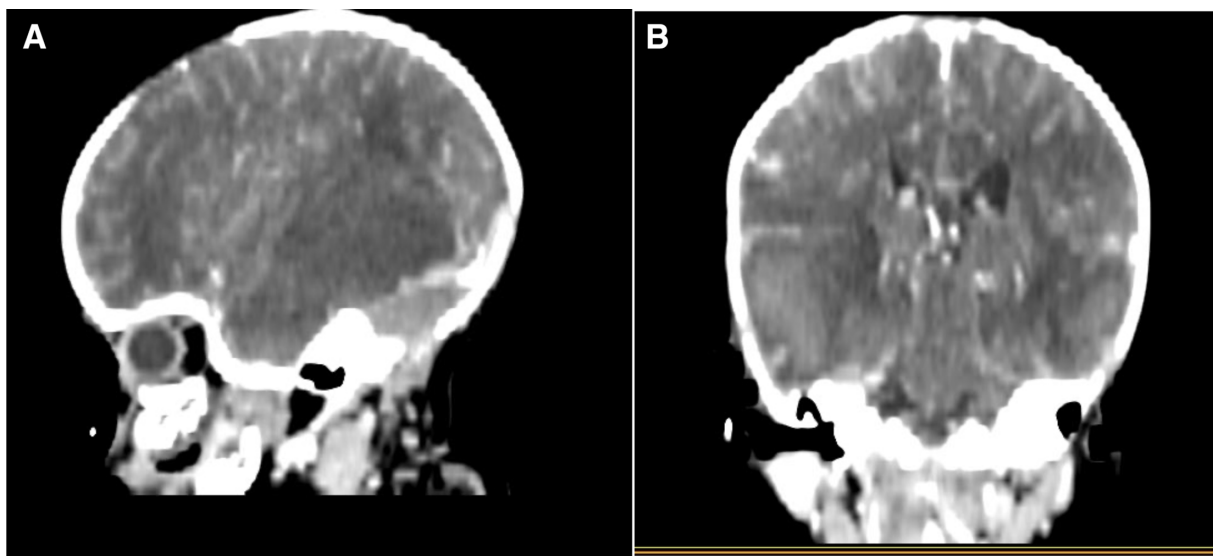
Sagittal and Coronal. (A and, B) Contrast E-enhanced CT shows bilateral multiple non- enhanced lesions with perilesional oedema at frontal temporal lobes and effacement of ipsilateral lateral ventricles noted.
